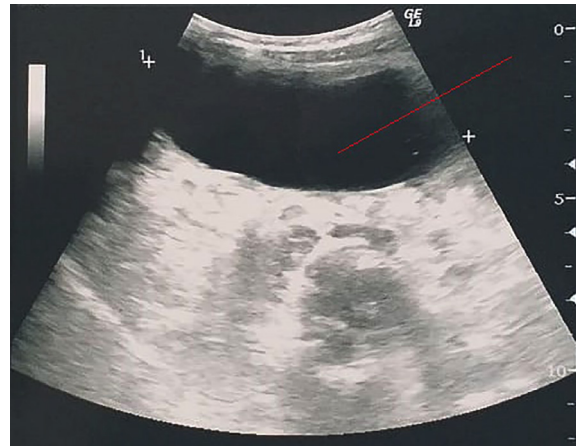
Ultrasonography shows a cystic mass in the peritoneal cavity.
